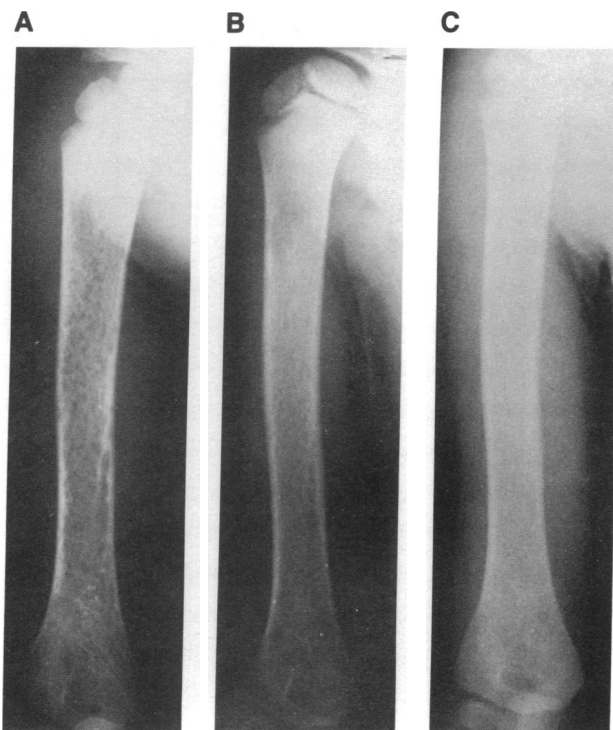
Comparison of x-ray films of the right humerus before and during enzyme administration. (A) Pretreatment. (B) Week 80. (C) Week 104. Increased mineralization, decreased endosteal scalloping, and a finer trabecular pattern developed during enzyme supplementation.
